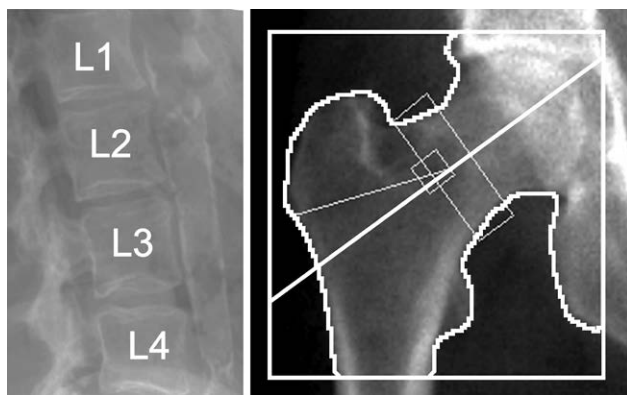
Example of a lateral single-energy image of the lumbar spine, with the lumbar vertebral bones L1–L4, and a proximal femur image for areal BMD assessment from dual-energy X-ray absorptiometry (DXA). BMD, bone mineral density.
